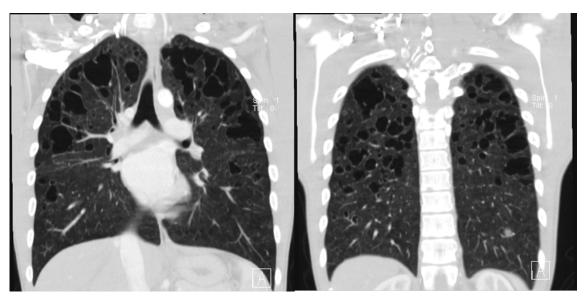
Coronal high-resolution CT images (lung window) showing diffuse lung cysts predominantly thin-walled, with bizarre shapes and various sizes, packed throughout the middle and upper lungs. There is relative sparing of the lung bases and costophrenic angles. Few nodules are also present.
